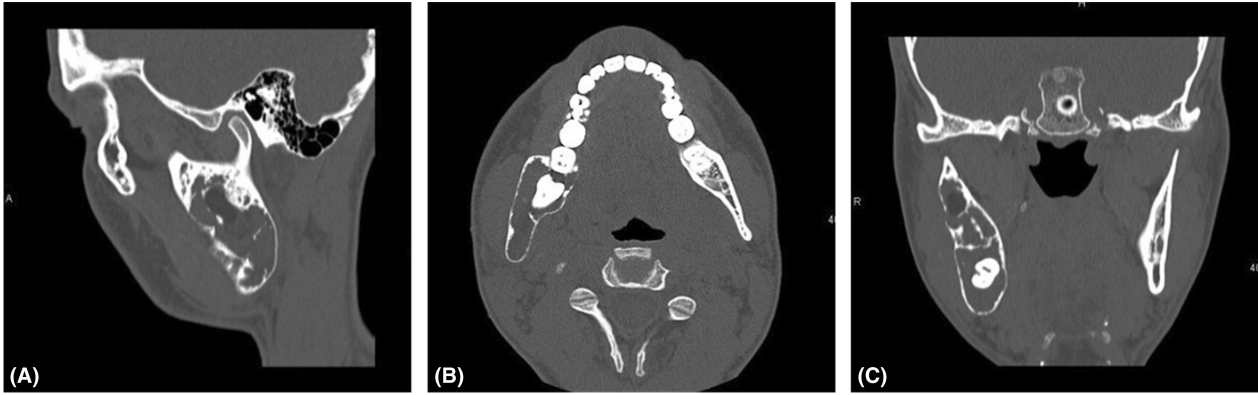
(A) Sagittal, (B) axial and (C) coronal planes of the CT scan showing cortical expansion. Taken at the initial assessment.
